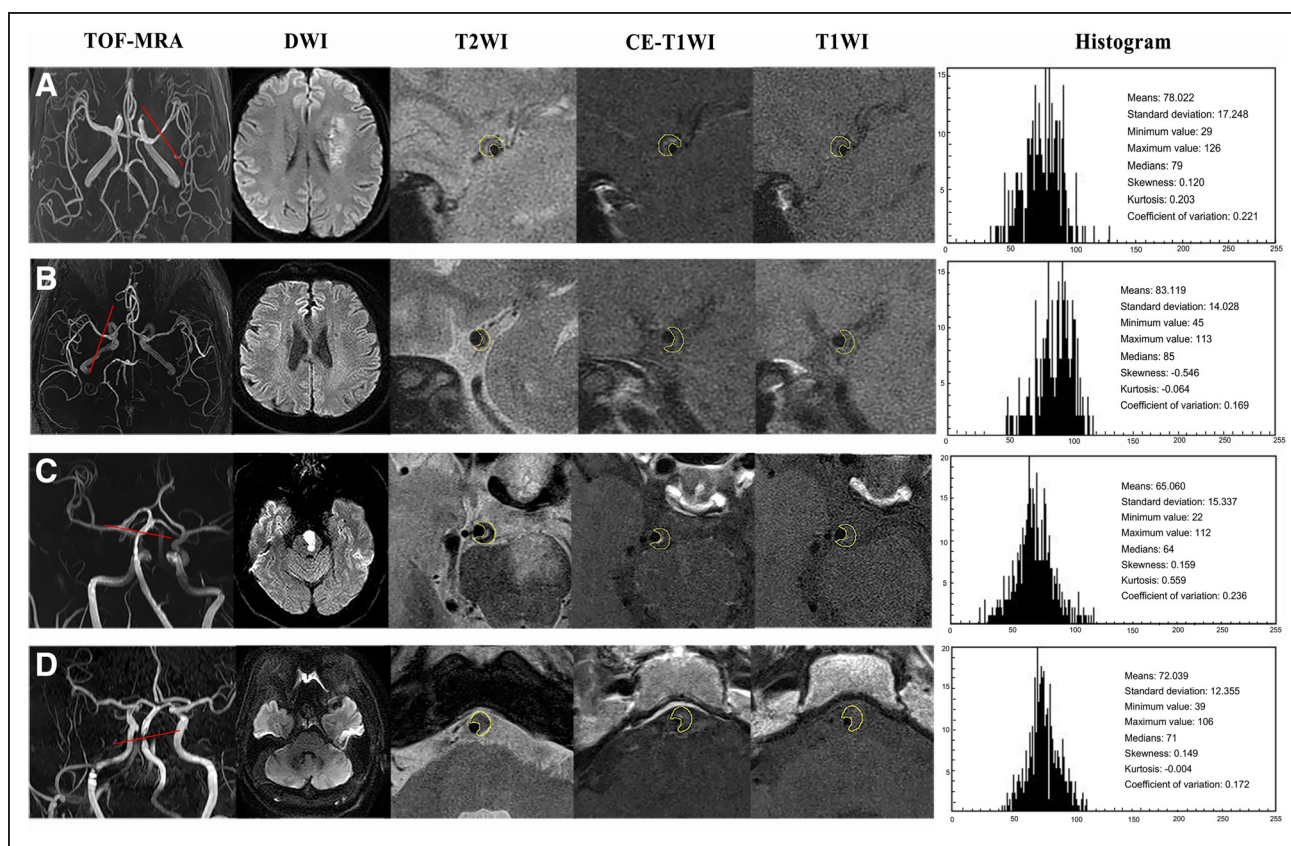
High-resolution magnetic resonance imaging (hrMRI) images and histogram showing atherosclerotic plaques in middle cerebral artery (MCA) and basilar artery (BA). A, A 64-year-old man with acute ischemic stroke on the left cerebrum.
